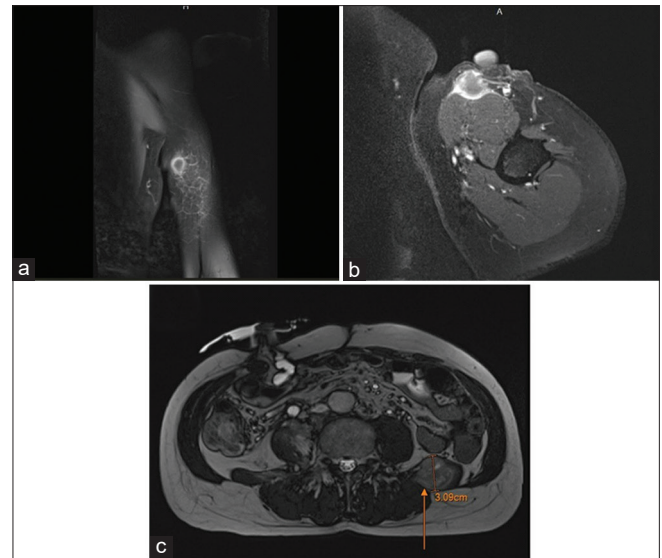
Left forearm magnetic resonance imaging (MRI) (a: coronal, and b: axial view, T1 with contrast) and abdominal MRI (c: axial view, T2) showing muscular metastases
